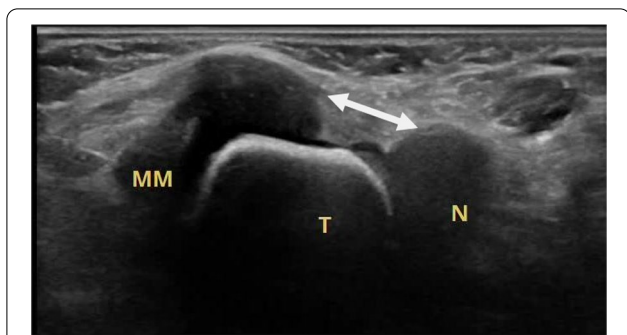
Ultrasound scan dorsal sagittal view of the left foot for a 12-day-old male newborn, presenting with club foot, which shows a decreased MMN distance in the neutral position
